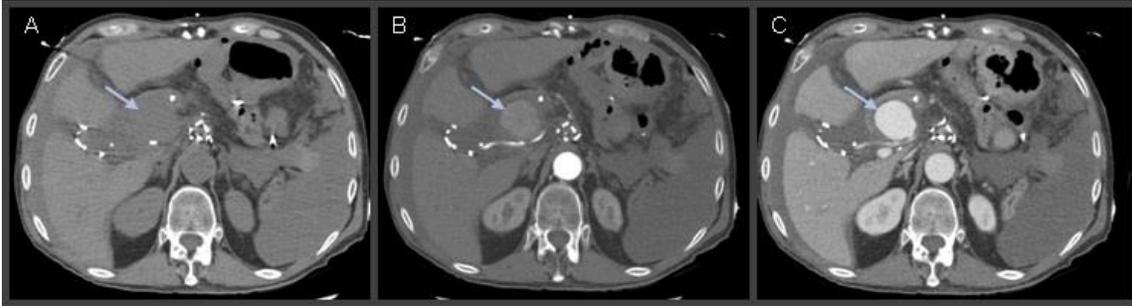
Axial images of the triple-phase CT scan demonstrating progressive contrast enhancement of the lesion (arrow) across non-contrast (A), arterial (B) and delayed (C) phases
